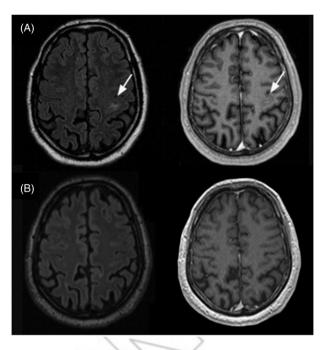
Neurosarcoidosis treatment response to prednisone. A: MRI of a 57-year-old patient with probable neurosarcoidosis. The singular FLAIR hyperintense, contrast-enhancing CNS lesion on T1-weighted images (arrows) is completely remittent after oral prednisone therapy (B). Courtesy of Dr S. Sartoretti, Winterthur.
